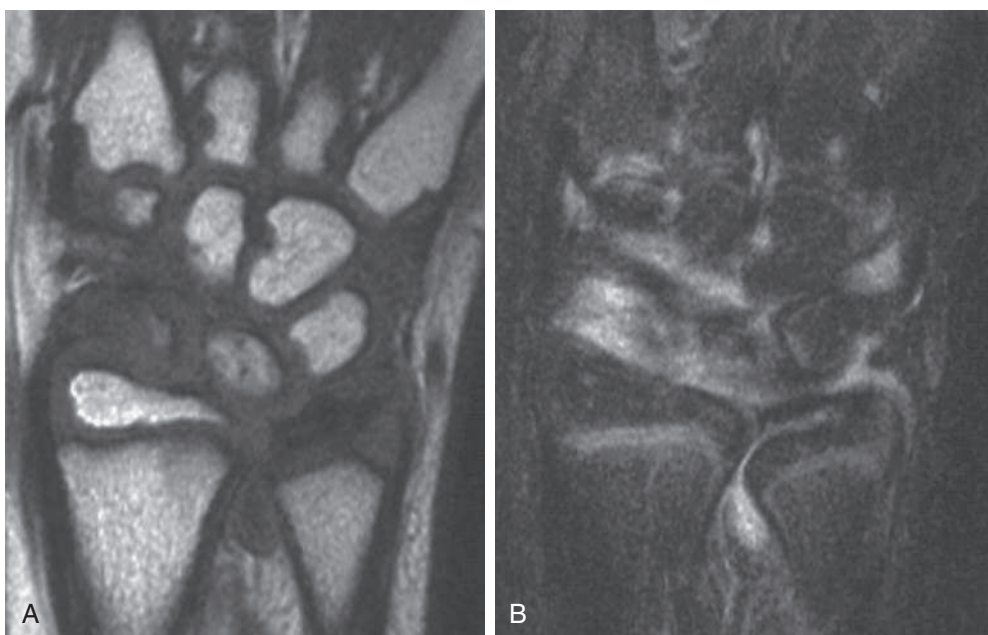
MRI of the wrist in a child with wrist arthritis. A, Multiple erosions of carpal bones. B, After administration of gadolinium contrast agent, uptake is consistent with active synovitis.
